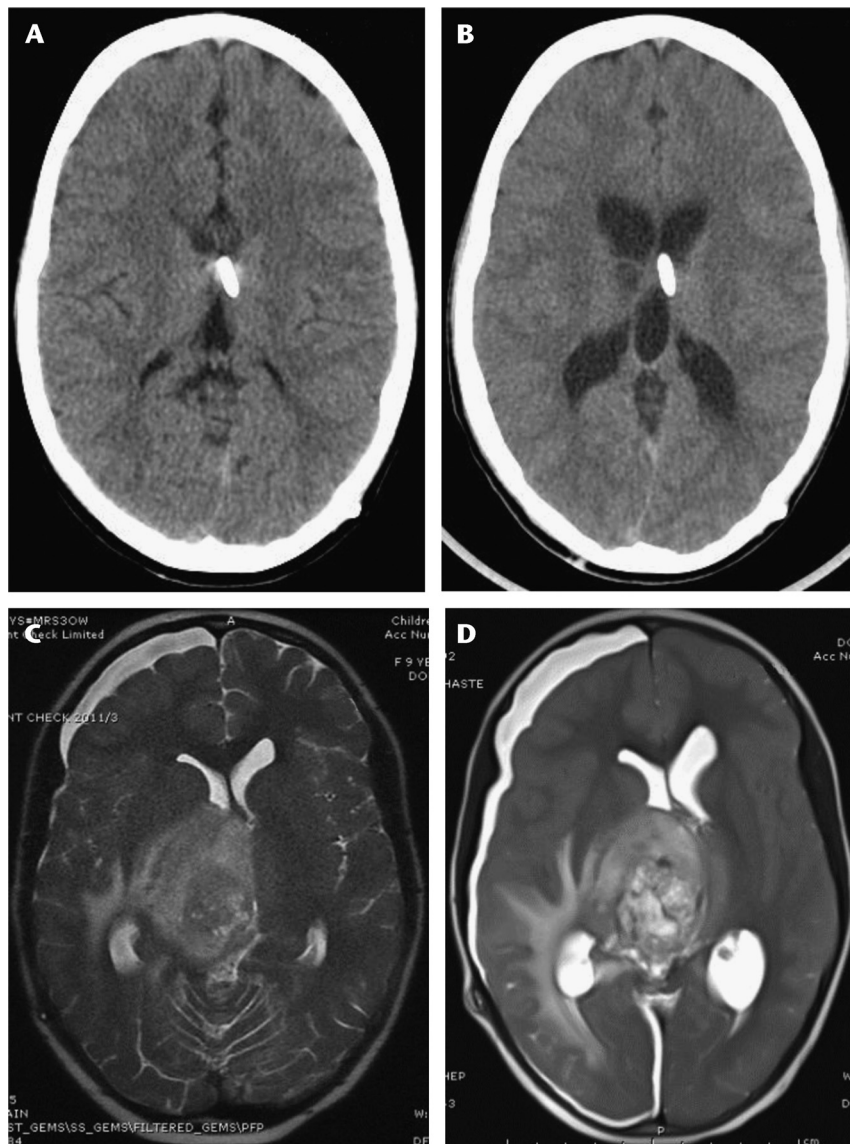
Representative axial images from 2 different patients with ventricular shunts at baseline (A and C) and with shunt malfunction (B and D) who underwent CT (A and B) or rapid cranial MRI (C and D).
